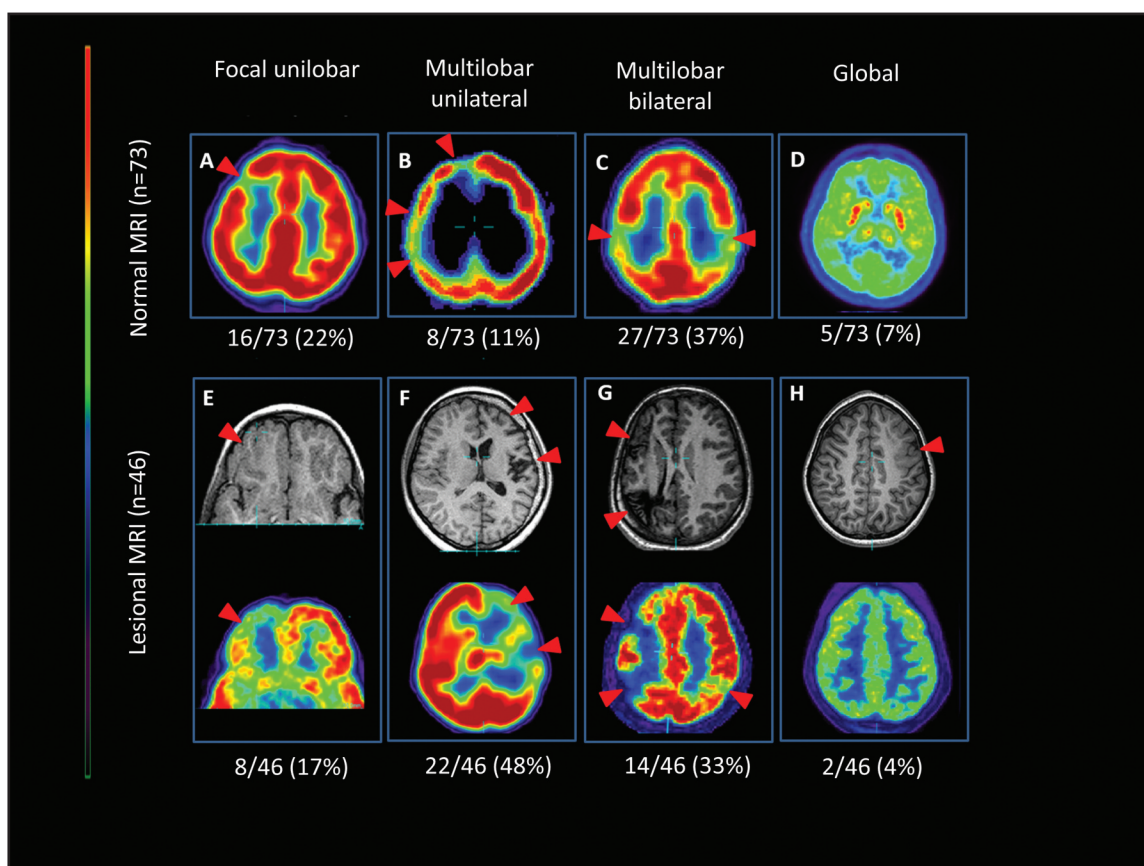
Patterns of <sup>18</sup>F-FDG PET hypometabolism seen in 56/73 patients with normal MRI (top row, A-D) and all patients with lesional MRI (bottom row, E-H). (E) T1-weighted axial MRI showing abnormal grey-white differentiation over the right orbitofrontal region and concordant focal hypometabolism, suggestive of focal cortical dysplasia, (F) T1-weighted axial MRI showing left frontotemporal atrophy in a patient with traumatic brain injury and concordant hypometabolism, (G) T1-weighted axial MRI shows multilobar encephalomalacia involving the right hemisphere in a patient with history of HSV encephalitis – PET detected additional left parietal hypometabolism where no clear lesion was seen on the MRI, (H) T1-weighted axial MRI showing thickened cortex and broad gyri in a patient with a poorly defined left frontal focal cortical dysplasia – PET was not helpful as it showed global hypometabolism. Colour scale: red = highest level of <sup>18</sup>F-FDG uptake, dark blue/violet = lowest level of <sup>18</sup>F-FDG uptake. Red arrowheads denote areas of abnormalities.
